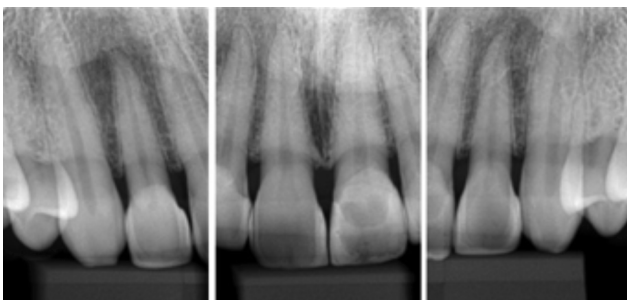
Radiographical follow-up after 10 years.
